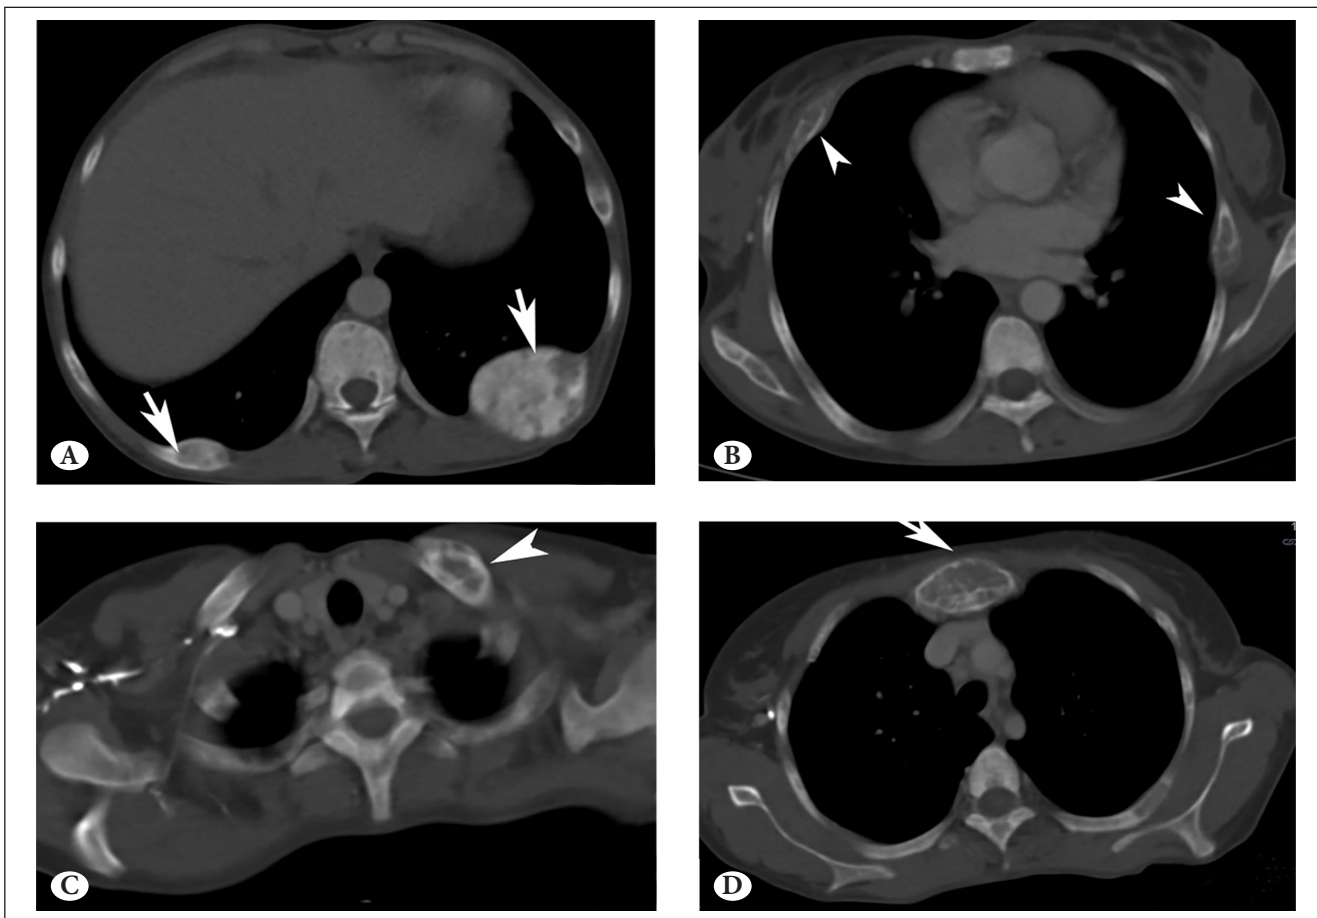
Computed tomography demonstrates a 40x45 mm expansile lytic lesion of the left posterior of the 10th rib, the right posterior of the 10th rib (A), right anterior of the 4th rib, left lateral of the 6th rib (B), the left clavicle (C) and corpus sterni with cortical destruction pattern (D).
